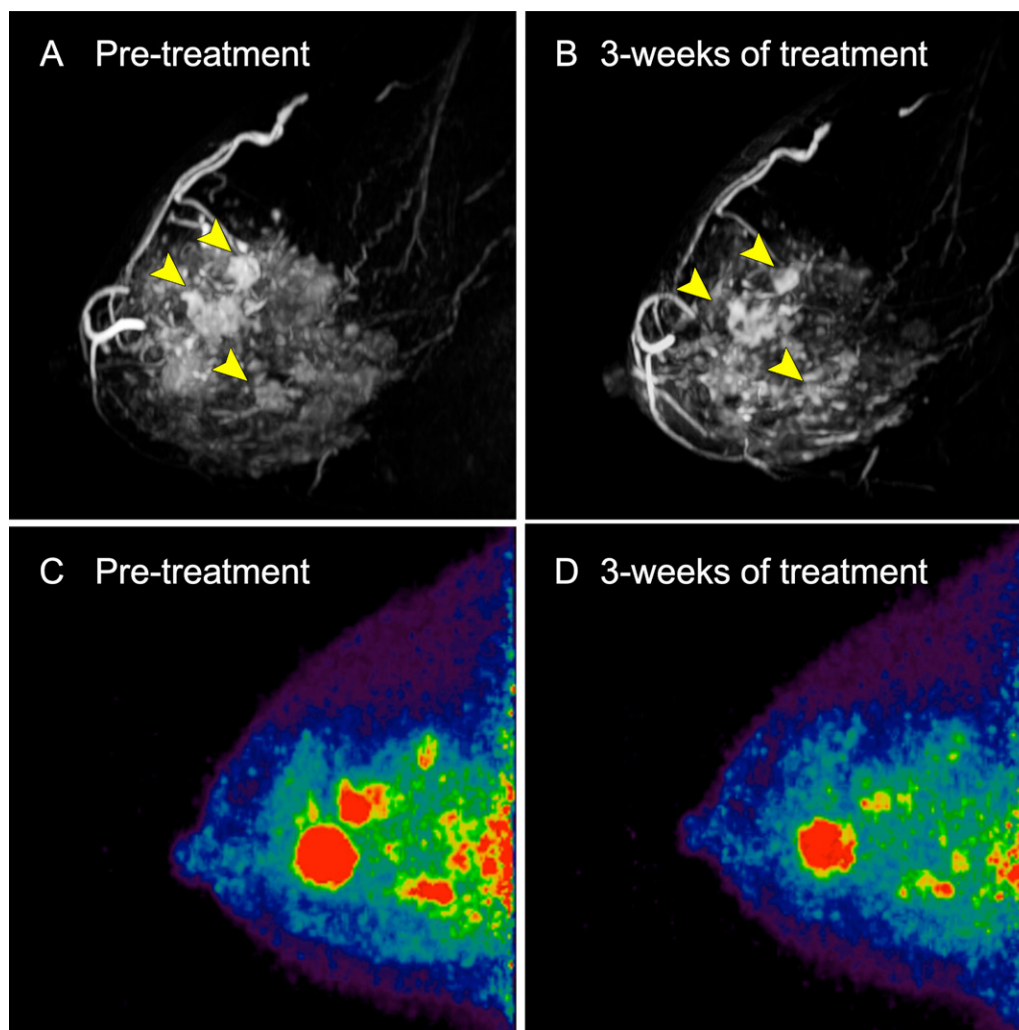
Images in a 42-year-old participant with estrogen receptor–positive/progesterone receptor–positive/human epidermal growth factor receptor 2–negative multifocal right breast cancer who was classified as having a nonresponsive tumor (residual cancer burden class 3). (A, B) Sagittal maximum intensity projection postcontrast T1-weighted MRI scans show a decrease in the volume of multifocal enhancing masses (arrowheads) from (A) baseline to (B) 3 weeks after treatment. (C, D) Sagittal maximum intensity projection dedicated breast PET images show a corresponding decrease in multifocal fluorine 18 fluorodeoxyglucose uptake from (C) baseline to (D) 3 weeks after treatment.
